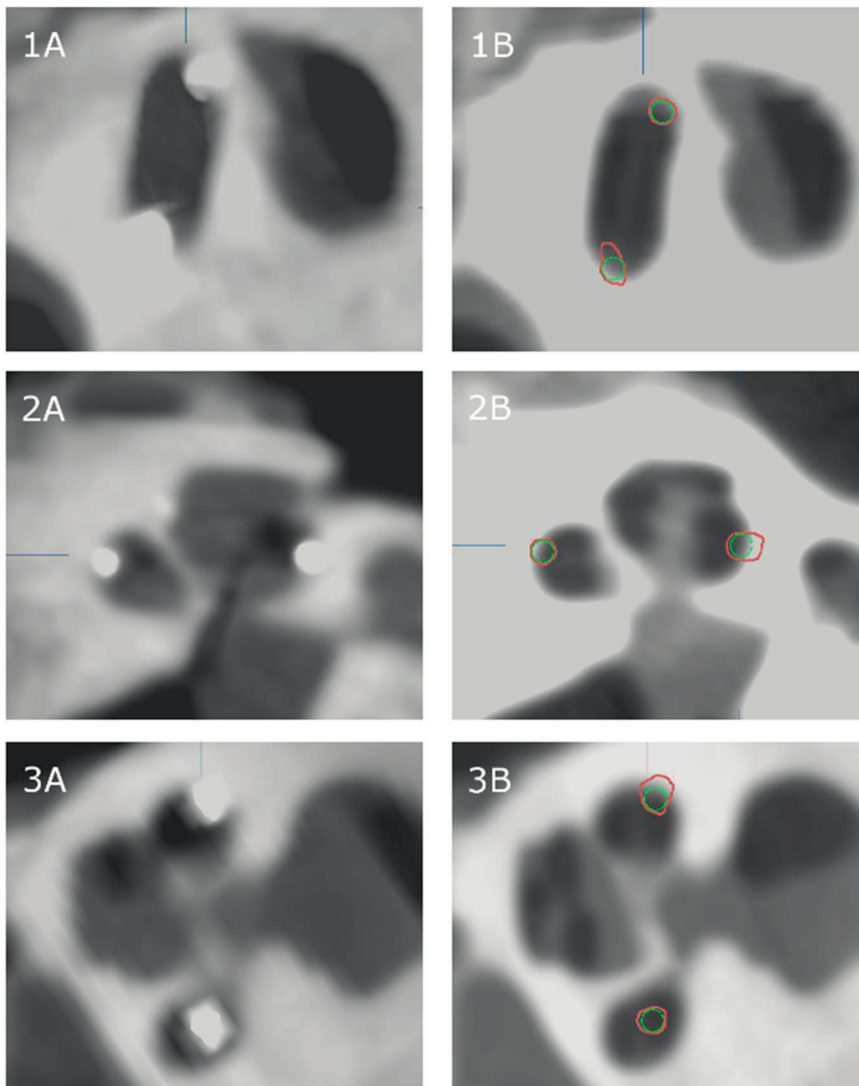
Trauma evaluations. 1A shows the CB-CT image and 1B shows the fusion image of TB 10, insertion traumas as Eshragi 3 in degrees 90 and 0 in 180 degrees and dislocation in CB-CT at 90 degrees. 2A shows CB-CT image with dislocation basal parts and scala tympani location approximately in 270 degrees. 2B is Eshragi grade 3 in basal part and grade 2 at 270 degree. 3A is scala tympani insertion and 3B are Eshragi grade 1 in TB 3 at 90 degrees and grade 0 deeper in cochlea.
